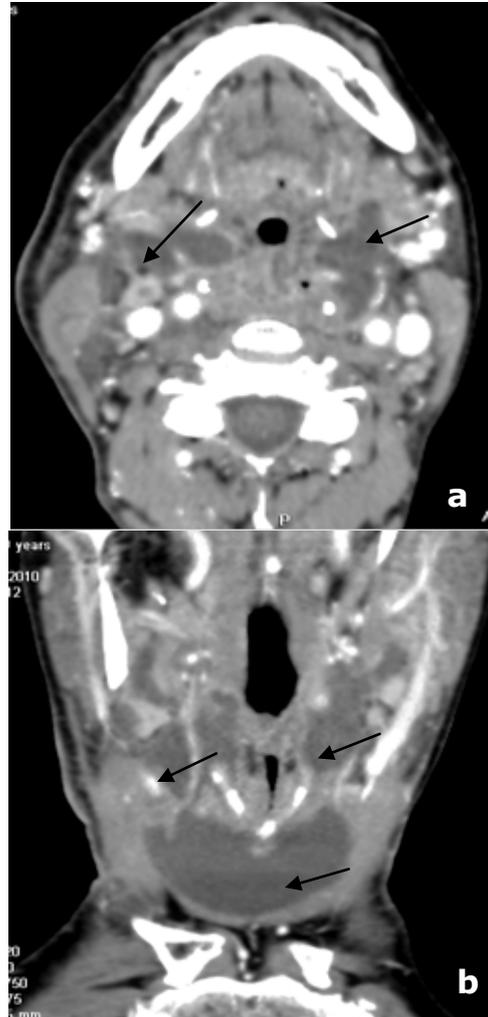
Axial (a) and coronal (b) CT views, in the parapharyngeal, carotid and anterior neck spaces multiple liquid collections, with an edge postcontrast density increase, could be seen
